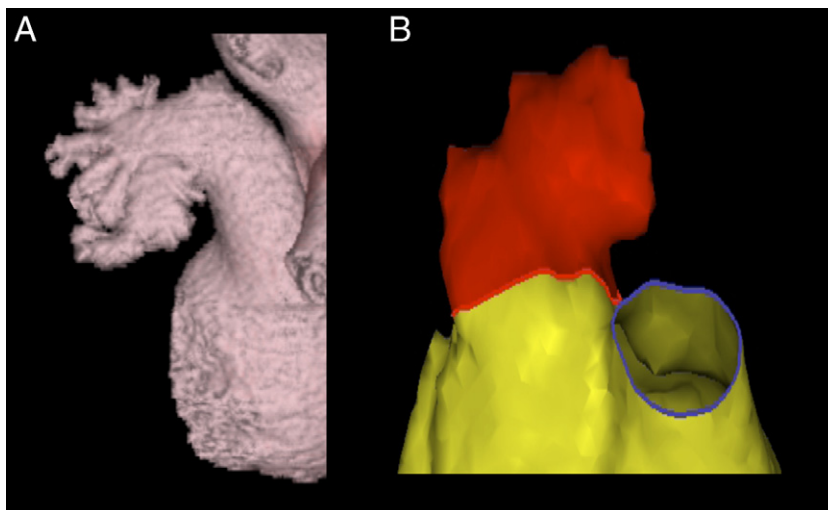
CT and MRI Scans of a Cauliflower LAA Morphology
